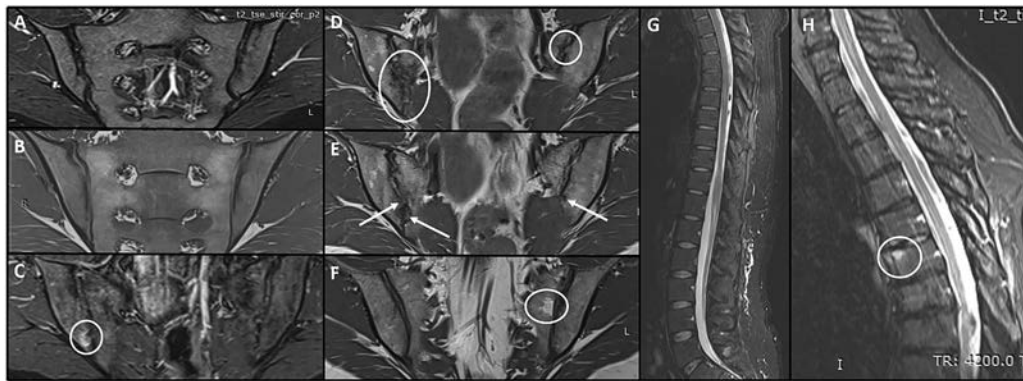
Examples of magnetic resonance images (MRIs) of the sacroiliac (SI) joints and spine in healthy, asymptomatic study subjects. A, SI joint MRI (short tau inversion recovery [STIR] sequence) in a 32-year-old female subject showing no bone marrow edema (BME). B, SI joint MRI (T1 sequence) in a 26-year-old male subject, displaying no structural lesions. C, SI joint MRI (STIR sequence) in a 31-year-old female subject showing limited BME (white circle) in the inferior ilium. D and E, SI joint MRI (T1 sequence) in a 31-year-old female subject (same as in C) displaying bilateral partial ankylosis (white circles in D, left arrow in E) and erosions (middle and right arrows in E). F, SI joint MRI (T1 sequence) in a 40-year-old female subject displaying limited sacral fat metaplasia (white circle). G, Spinal MRI (TIRM sequence; T4–L5) in a 25-year-old female subject showing no corner inflammatory lesions. H, Spinal MRI (TIRM sequence; C6–T9) in a 49-year-old female subject displaying an anterior corner inflammatory lesion (T6) (white circle).
